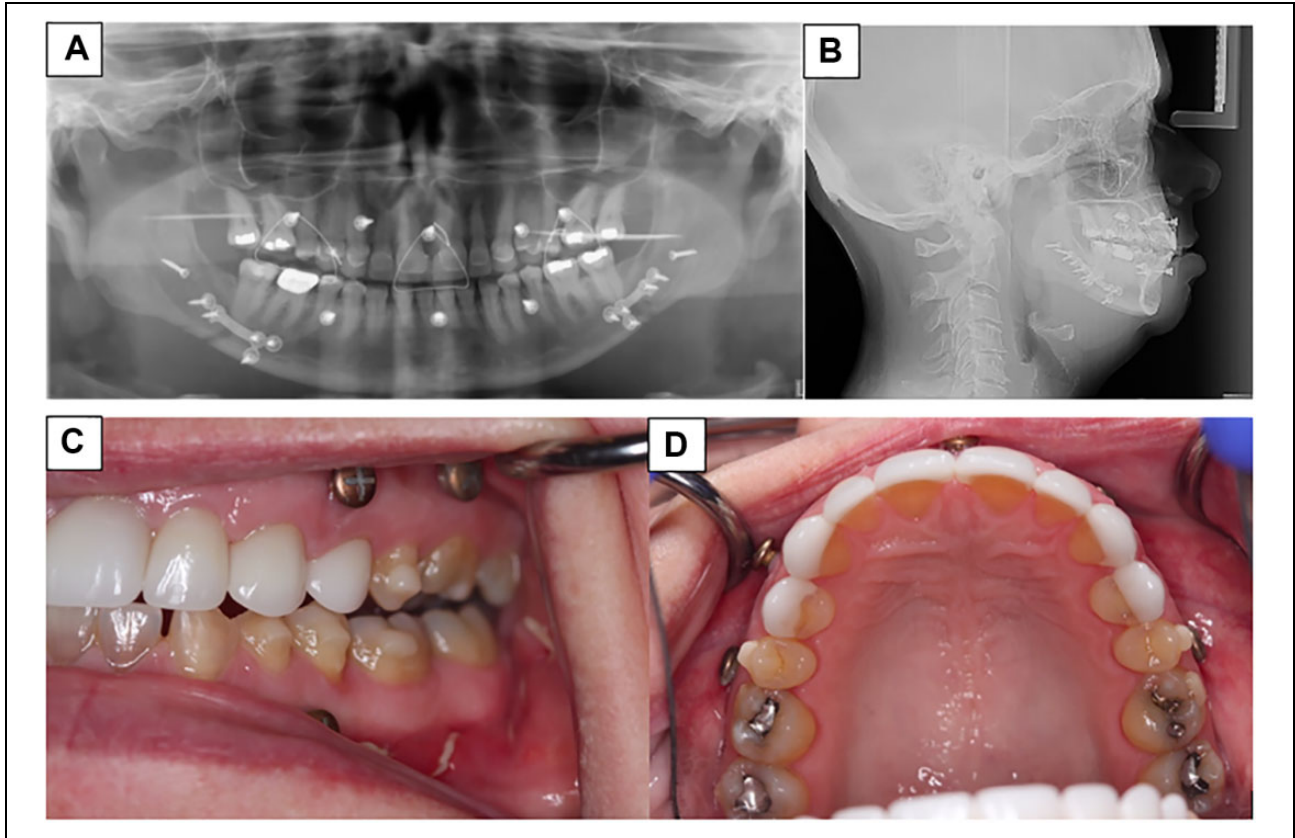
Postoperative orthopantomogram (A) showing MatrixWAVE MMF screw and wires in place, and postoperative lateral cephalogram (B) and postoperative photographs (C and D) showing MatrixWAVE MMF screws in place. MMF indicates maxillomandibular fixation.
